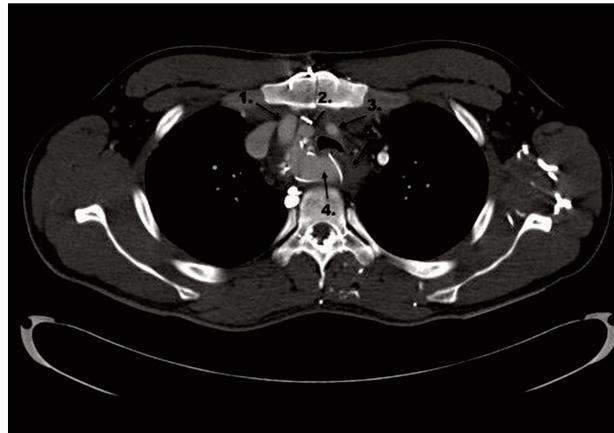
An axial plane contrast-enhanced CT image post-operatively. The RAA branches off first to give the RSA graft (1). The RCCA graft (2) and LCCA graft (3) is also seen. The pseudo-aneurysm (4) has been reduced and the aberrant LSA (5) is not seen.
